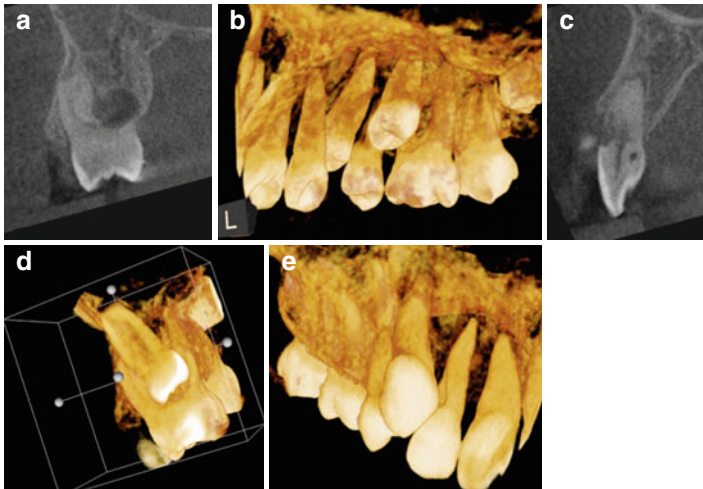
Continuation of case from Fig. 2.5. (a) Coronal view of the mesial furcation of tooth number 3 demonstrating the resorptive defect in the furcation and mesio-palatal aspect. (b, d) are 3D reconstructions demonstrating the same pattern from the palatal and mesial views, respectively. (c) Sagittal view of tooth number 7 demonstrating resorption caused by the ectopic eruption of tooth number 6. (e) 3D reconstruction demonstrating the relationship between teeth numbers 6 and 7. The information obtained from this CBCT scan will have a significant impact on orthodontic treatment planning
